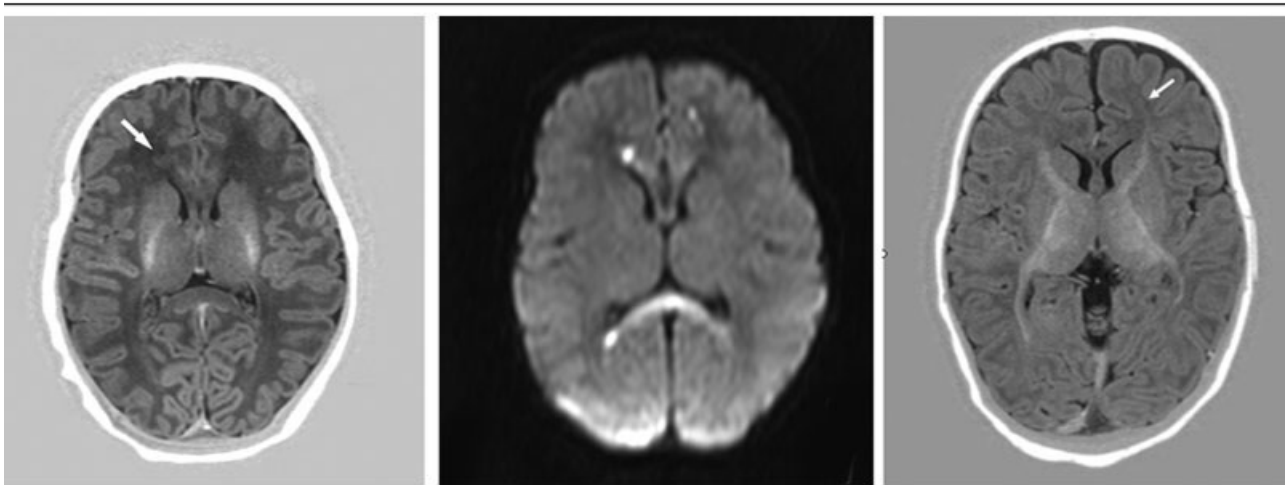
Magnetic resonance imaging (MRI) inversion recovery sequence (left) and diffusion-weighted imaging (middle) 6 days after the onset of human parechovirus (HPeV) infection (Patient 10). Note single high signal intensity punctate white matter lesion adjacent to the right frontal horn (arrow) (left) and multiple punctate white matter lesions, as well as increased signal intensity in the corpus callosum on diffusion-weighted imaging in this infant who did not present with clinical seizures. (middle) MRI at 3 months shows residual white matter abnormalities (arrow) (right).
